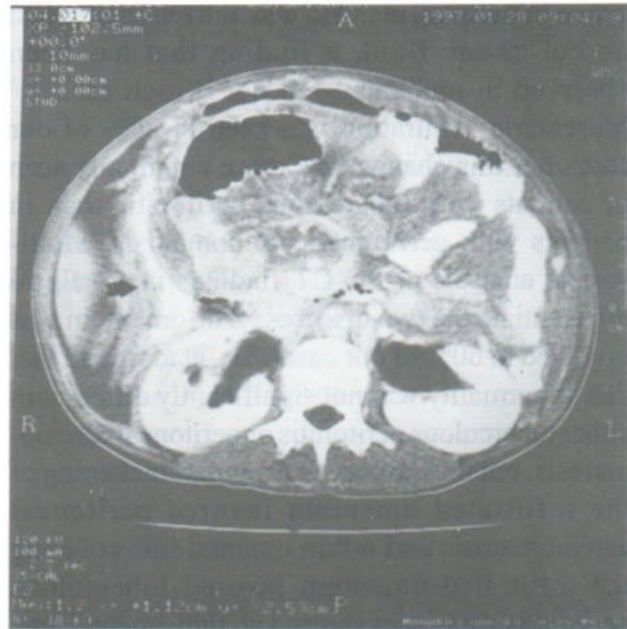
A 22-year-old woman with carcinomatosis peritonei due to disseminated NHL. Contrast enhanced CT scan shows thickened wall of ascending colon (arrow), ascites and thickened mesenteric leaves.
